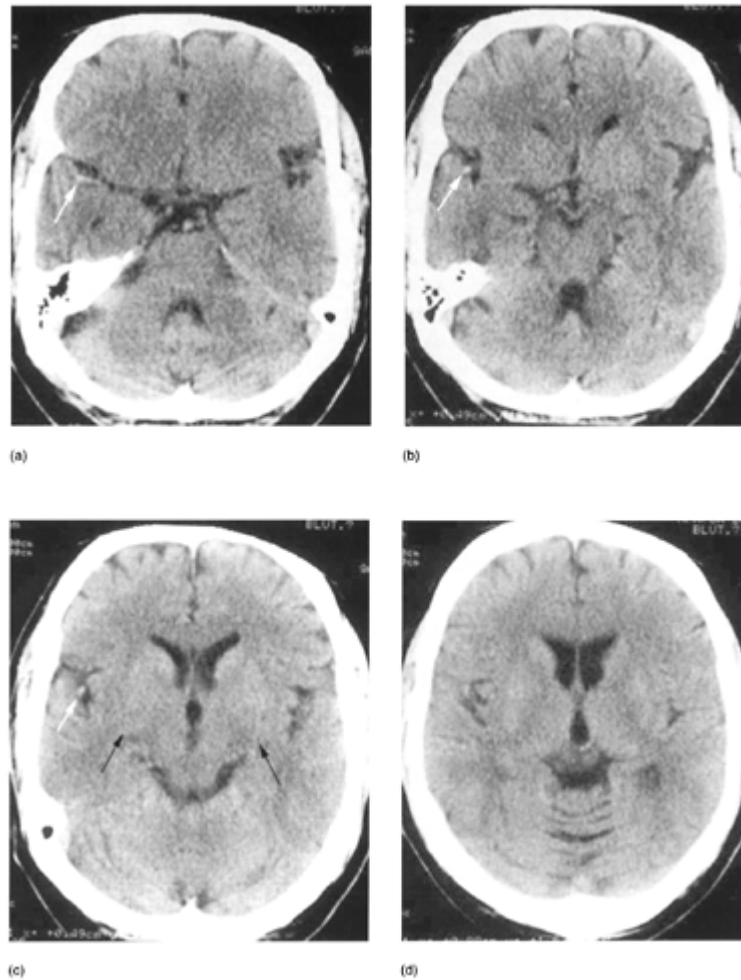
Unenhanced CT in a 54-year-old man with some weakness and numbness of his left hand for 2 hours.
